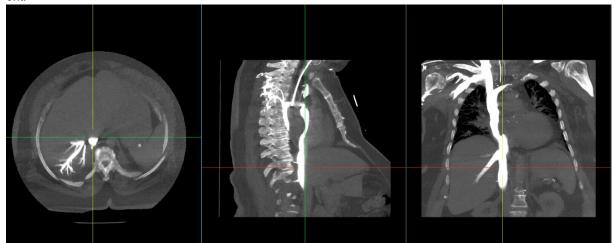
Axial sagittal and coronal reformatted CT sections (left to right, respectively). Dependent venous pooling and layering of contrast material within SVC, right atrium, IVC, and other dependent venous structures.
